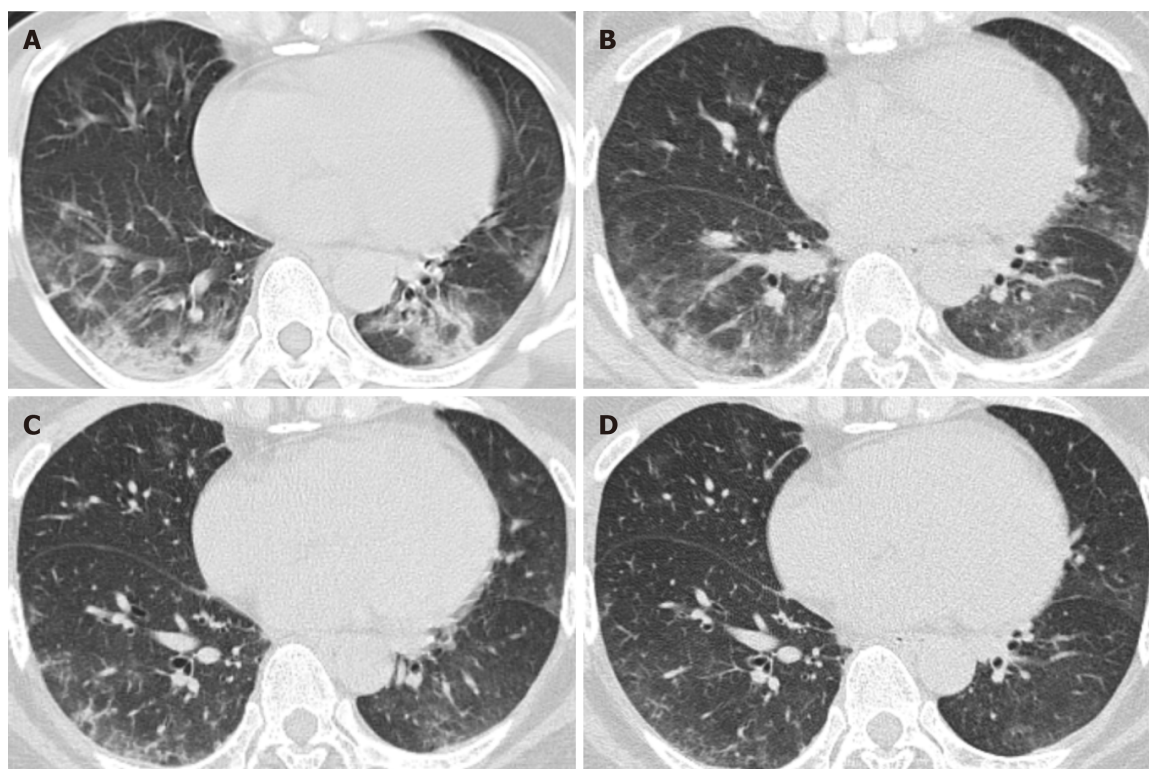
Unenhanced computed tomography images in a 49-year-old woman (axial imaging). Computed tomography (CT) radiographs show multiple patchy ground-glass opacities and consolidated opacities in bilateral lower lobes, the middle lobe of the right lung and the tongue segment of the upper left lung, as treatment progressed, CT manifestations showed improvement. A: Day 7 (2020.1.26) after the onset of symptoms; B: Day 12 (2020.1.31) after the onset of symptoms; C: Day 16 (2020.2.4) after the onset of symptoms; D: Day 21 (2020.2.9) after the onset of symptoms.
